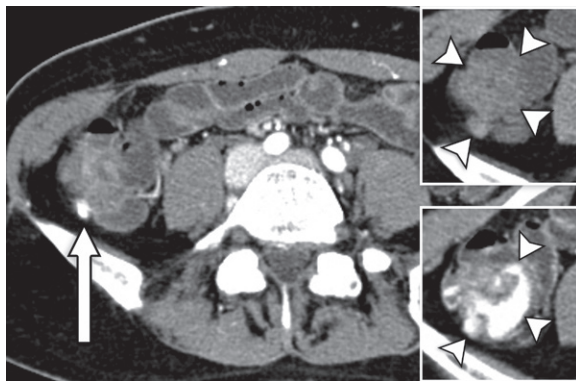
Active bleeding from a cecal diverticulum in a 46-year-old woman with hematochezia. Axial contrast-enhanced arterial phase (main image), noncontrast (top inset), and portal venous phase (bottom inset) CTA images show active extravasation within a cecal diverticulum in the arterial phase (arrow in main image) and further accumulation of contrast extravasation within the colonic lumen in the portal venous phase (arrowheads in bottom inset). The noncontrast image shows a sentinel clot within the cecum and cecal diverticulum (arrowheads in top inset). Figure E6 is a colonoscopic image that shows a blood clot at the orifice of the bleeding diverticulum.
